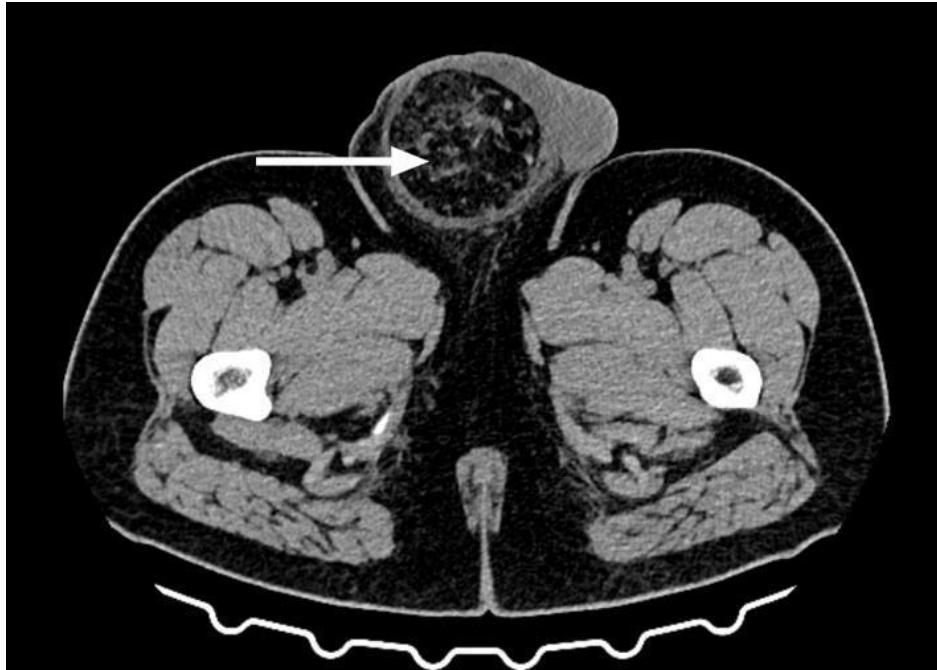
Plain CT abdominal axial section: Diffuse omental fat stranding seen herniating into the right scrotal sac.
